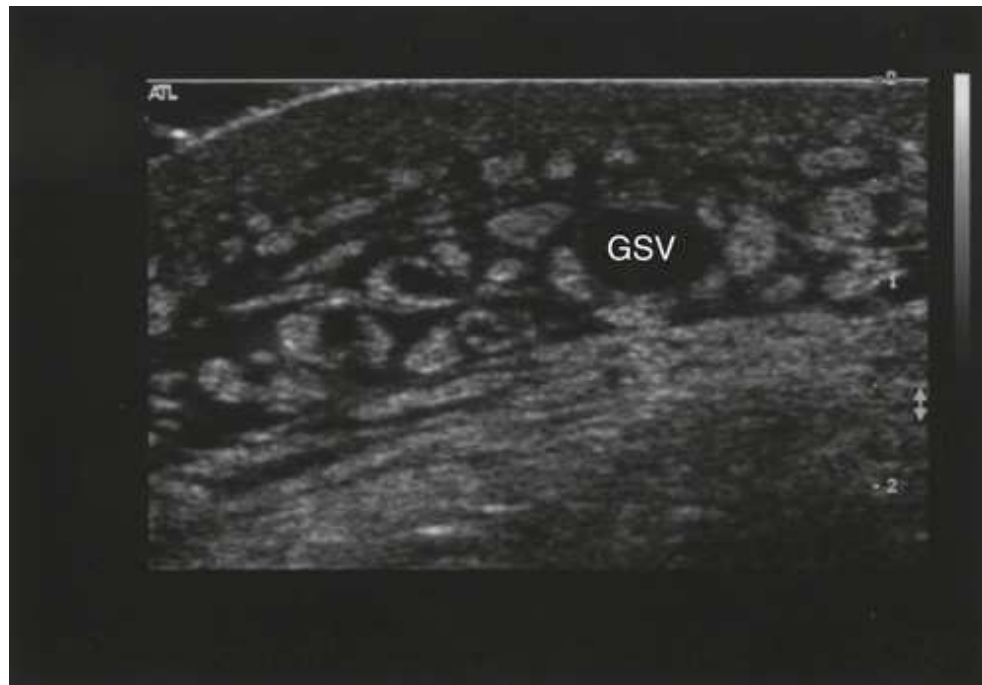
Transverse sonogram of medial thigh shows tissue edema surrounding great saphenous vein (GSV).
